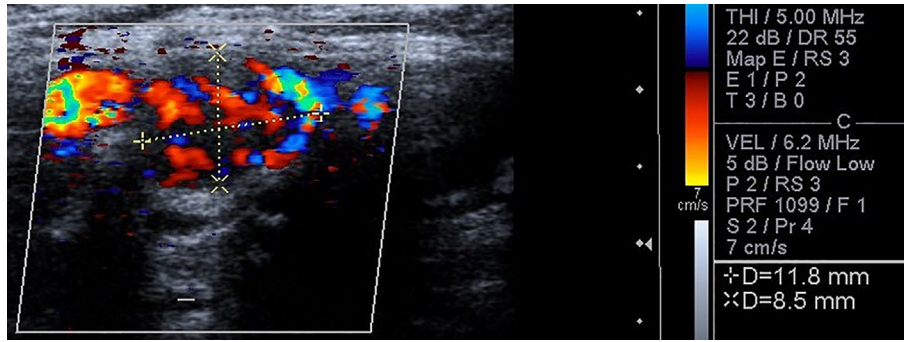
Duplex ultrasound showing the carotid body tumor.
